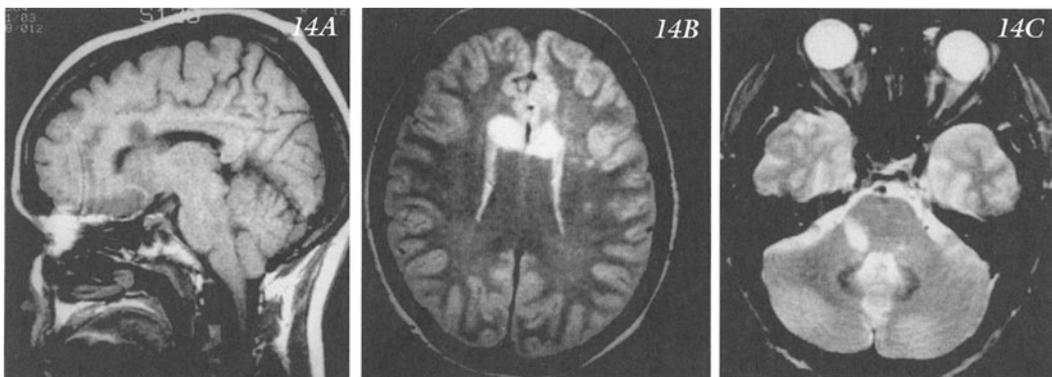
MRI. Multiple sclerosis. This 47-year-old female farm owner and manager had a 2-month episode of numbness ("novocaine type sensation") over the entire right trigeminal distribution. Five years previously she had intermittent unsteadiness. Her examination demonstrated only a selective decrease in touch sensation over the entire right trigeminal distribution. The MRI studies confirmed a right mid pontine tegmental lesion but also indicated multiple areas of demyelination in the white matter of the cerebral hemispheres particularly involving the corpus callosum. A) T1 sagittal, (B) T2 horizontal views, (C) T2 axial of brain stem.
